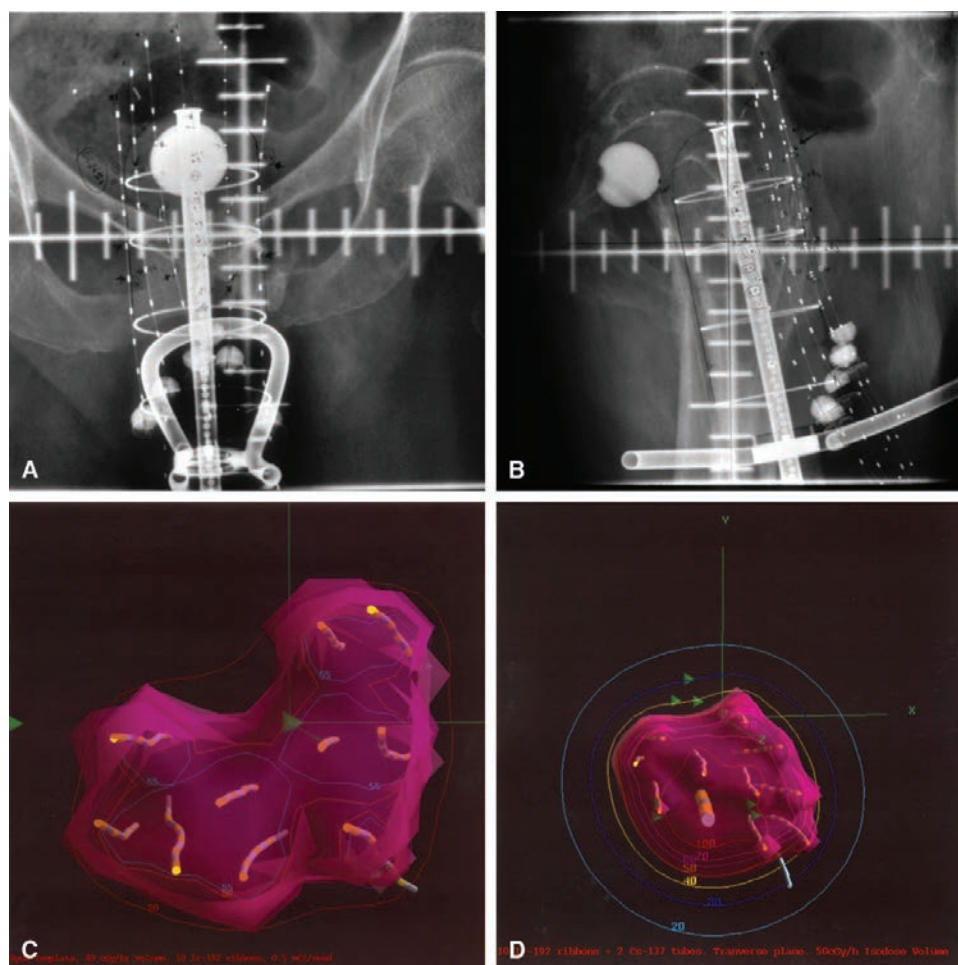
A: AP and B: lateral radiographs of an interstitial and intracavitary implant in carcinoma of the vagina using the modified Syed-Neblett template. C: Three-dimensional isodose distribution, Ir¹⁹² only; D: Ir¹⁹² plus Cs¹³⁷.
